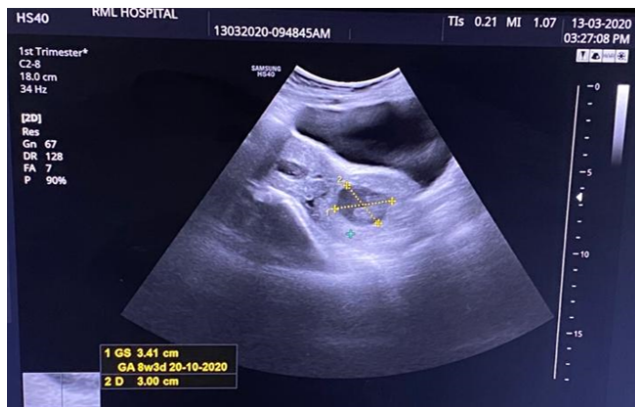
Transvaginal ultrasonography image showing gestational sac of 8 weeks 3 days in the endocervical cavity
